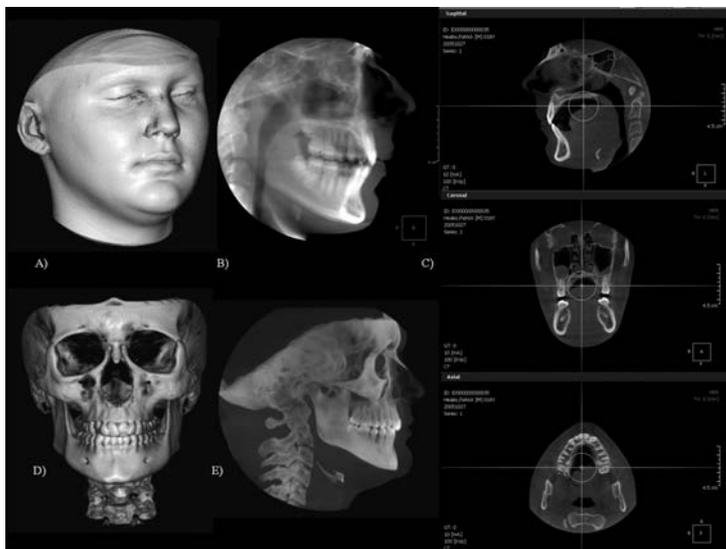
There are several possible ways to visualize a CBCT image. A) soft tissue view using the surface mode, B) radiographic mode, in which the 3D image is turned into 2D as in a traditional radiography, C) slice view, divided by sagittal, coronal, and axial view, D) skeletal rendering using the surface mode, and E) maximum intensity projection (MIP) mode which provides a 3D radiographic view.
